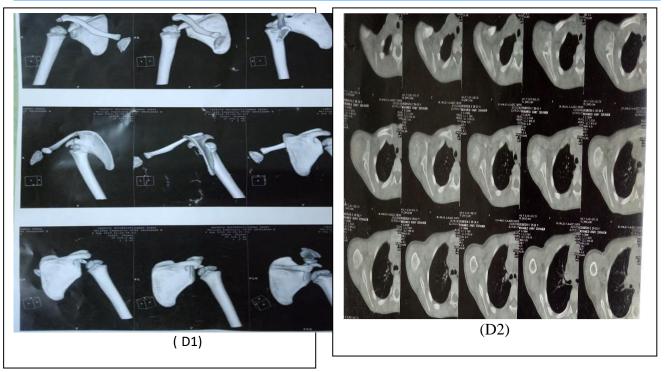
(A, B) Pre operative clinical evaluation (a.abduction. b.hand to mouth , c.hand to neck , d.hand to spine , e.ext.rotation) (B) pre operative radiological evaluation (B1: CT of affected shoulder B2:.axial view of shoulder), (C) Post operative clinical evaluation (a.abduction. b.hand to mouth , c.hand to neck , d.hand to spine , e.ext.rotation), (D) post operative radiological evaluation after 6 months (D1.3D CT of shoulder, D2.axial view of shoulder).
